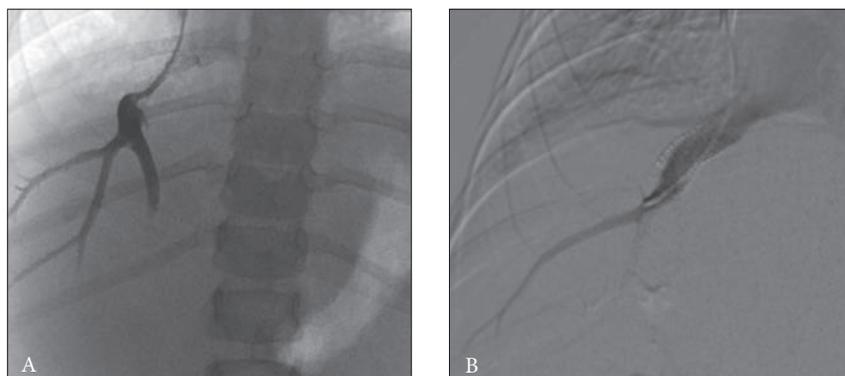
Hepatic vein stenosis in a 6-year-old patient with a split liver transplant for treatment of biliary atresia. The patient had refractory ascites and abnormal Doppler US findings 1 year post transplant. (A) Hepatic venogram shows a severe anastomotic stenosis with a pressure gradient of 30 mmHg. There was poor response to multiple angioplasties with balloons up to 10 mm in diameter. (B) Because of the poor response to angioplasty, a 10 mm diameter metal stent was deployed across the anastomosis with good imaging and clinical results. (US = ultrasound.)
